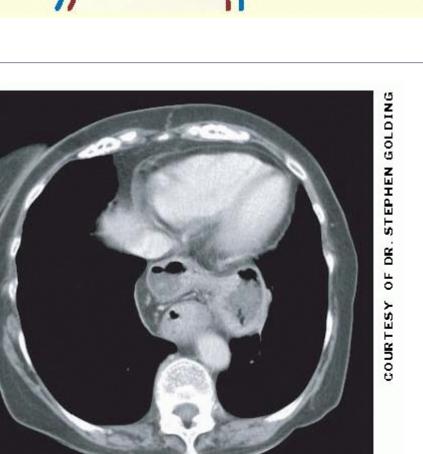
CT chest with IV contrast showing the rolling components of a hiatus hernia anterior to the oesophagus. Between the oesophagus and the vertebral coloumn on the left hand side, is the aorta.
